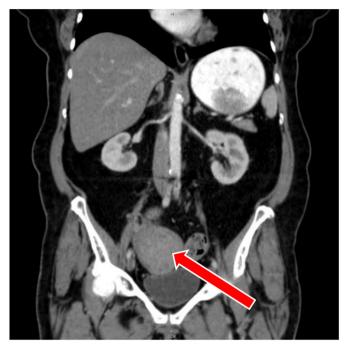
Computed tomography 8 cm well-circumscribed mass (arrow) in the right adnexal region which is in close association with the uterine fundus and adjacent bowel.
